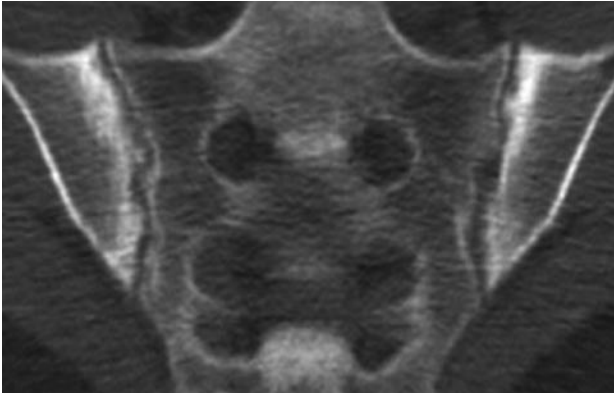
Computed tomography of sacroiliac joint shows bilateral subchondral sclerosis and dentate joint contour due to bone erosion.
